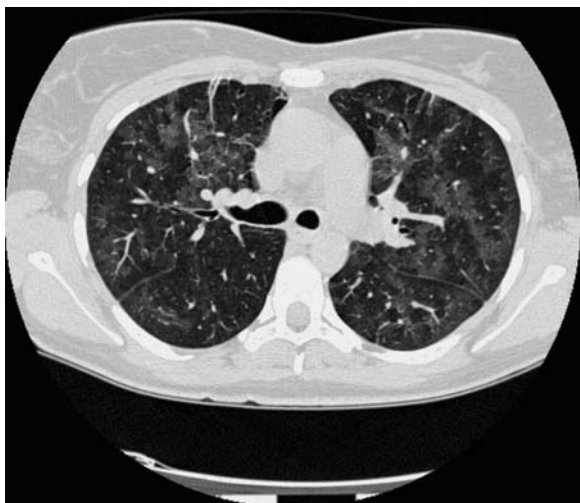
Pneumocystis carinii* pneumonia in a 36-year-old HIV-positive woman. Chest CT scan (collimation 12×0.75 mm) shows extensive, bilateral areas of ground-glass opacity which are found in a geographic distribution
